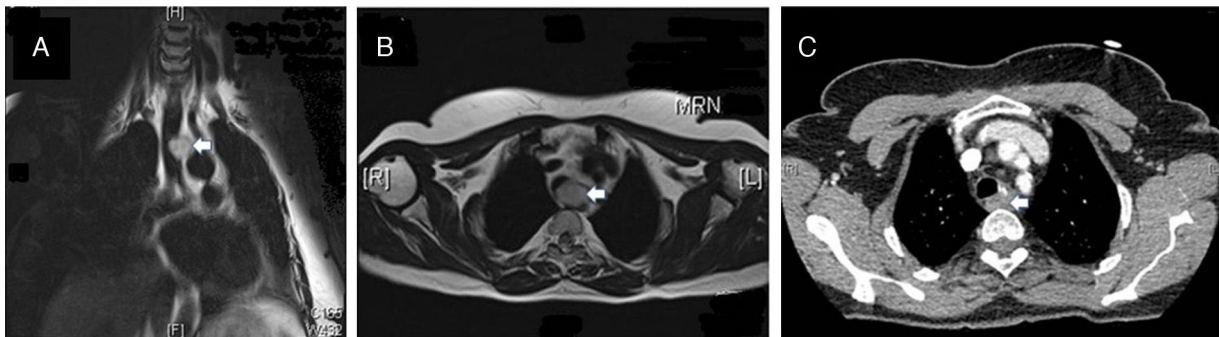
Magnetic resonance imaging showing the tracheal tumor (arrow) in sagittal (A) and coronal (B) planes compressing the esophagus but without invasion. (C) Follow-up chest CT 8 months after interventional endoscopy, demonstrating residual tumor (arrow).
